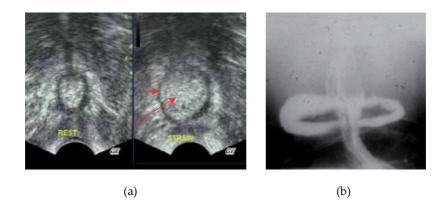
Sixty-two year-old woman under pharmacological treatment for psychological depression, with history of obstetric trauma, chronic constipation and episodes of passive fecal incontinence of recent onset. Integrated diagnostic work-up including perineal sonography (a) and defecography (b) within the same session: at sonography, thinning of the internal anal sphincter (short arrow) on straining and significant increase of the submucosal space (long arrow) suggestive of full-thickness intussusception. At defecography, involuntary barium loss during retrograde injection (not shown) and evidence of rectoanal intussusception with typical "Saturn's ring" sign due to entrapment of contrast on emptying within the double layer mucosa infolding.
